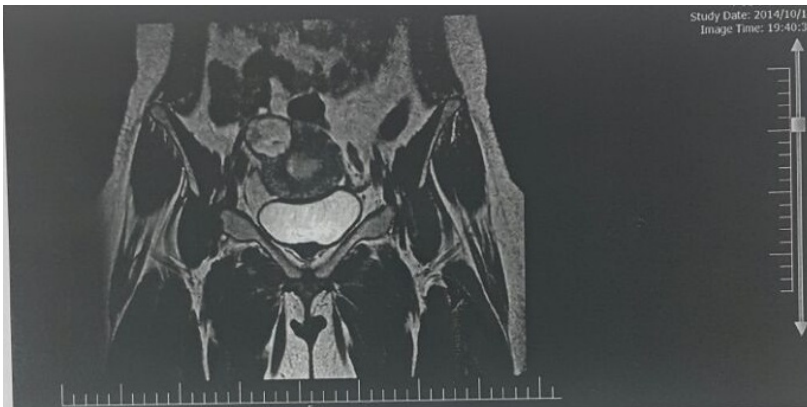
Sagittal view of pelvic MRI
